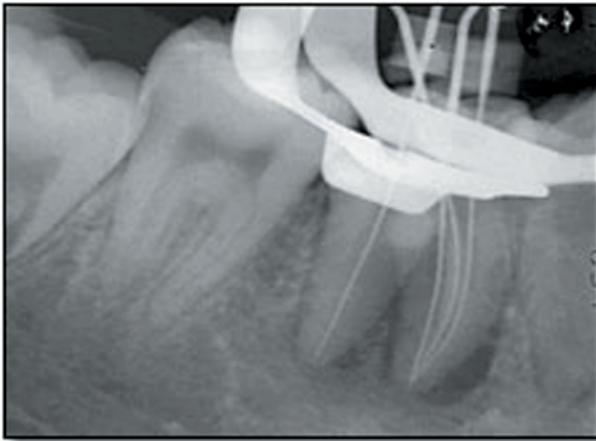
Working length determination radiograph showing three distinct and independent canals.
